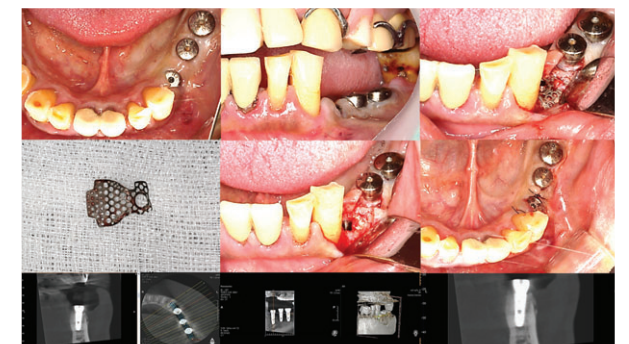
2nd-operative radiograph & Intra-operative view
